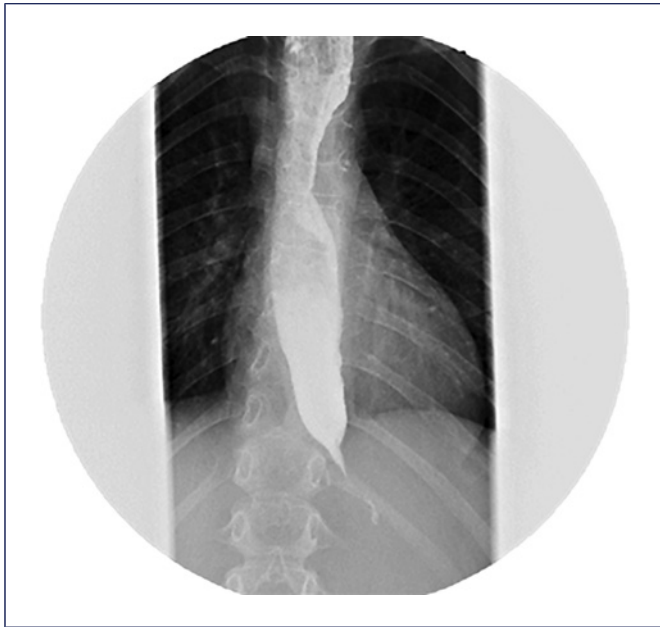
Esophageal X-ray with contrast showing a persistently narrowed region at the end of the esophagus with a dilated esophagus above the narrowed region.
